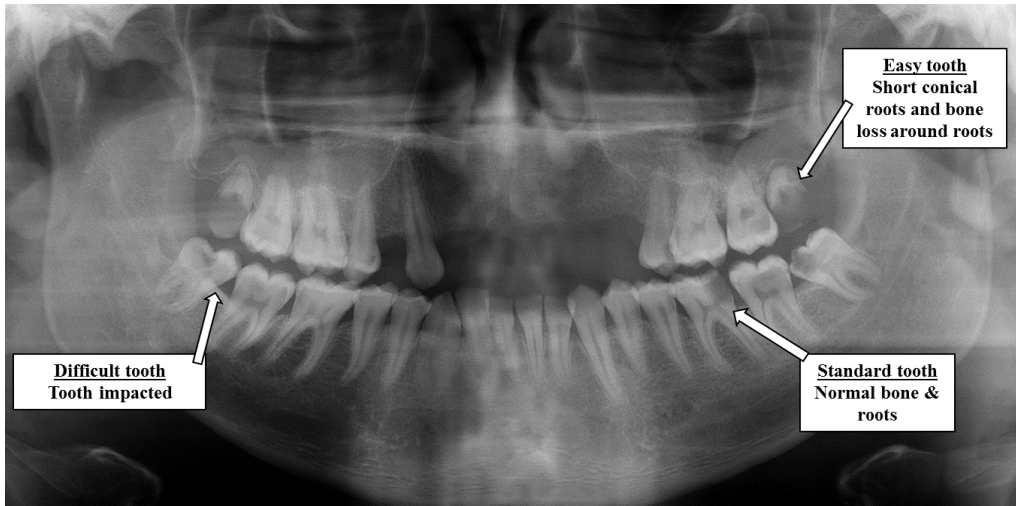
Orthopantomogram of clinical patient
